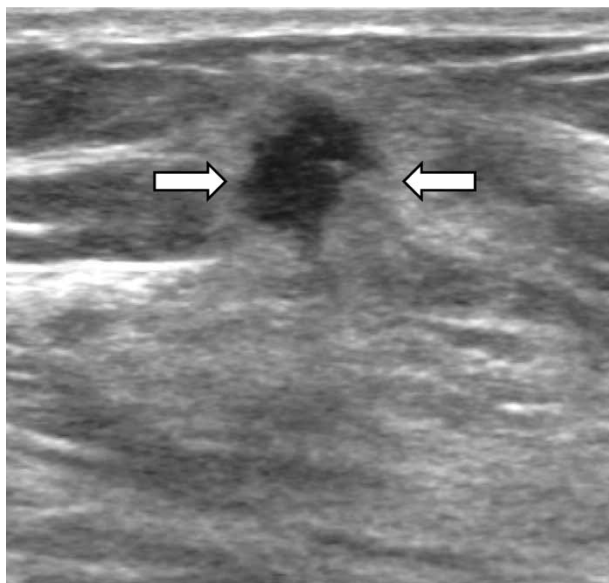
A 44-year-old female with a grade 2 invasive ductal carcinoma. Ultrasound shows an irregular shaped, not circumscribed marginated, hypoechoic, not parallel orientated mass (arrows) with an echogenic halo boundary. The cancer was ER and PR positive, and HER-2/*neu* negative.
